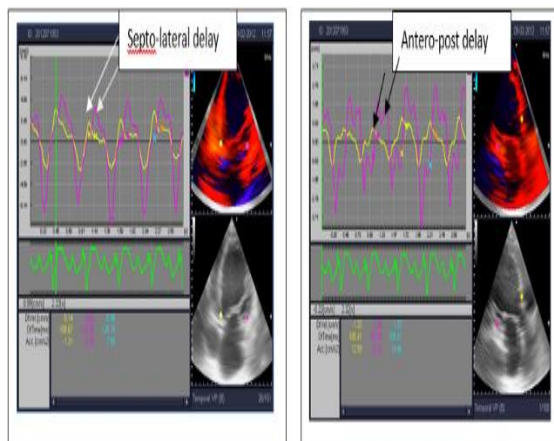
Assessment of intraventricular dyssynchrony with tissue Doppler technique (a) septolateral delay of 120 ms (b) there is antero posterior delay of.
